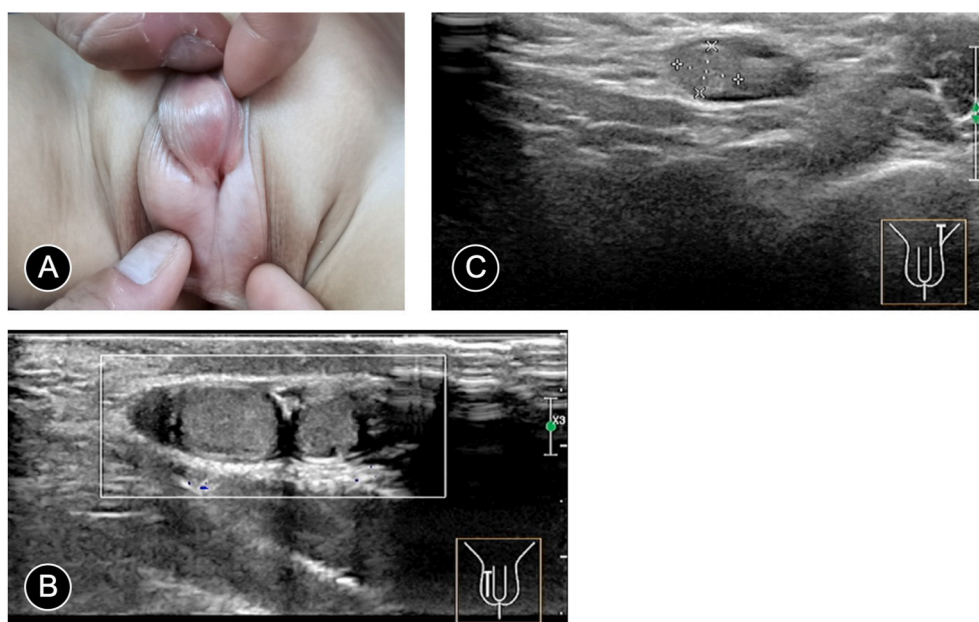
Physical examination and preoperative scrotal ultrasound of a child with hypospadias and polyorchidism: A. Preoperative condition of hypospadias in the patient. B. Two testes in the right scrotum. C. One testis in the left scrotum.
